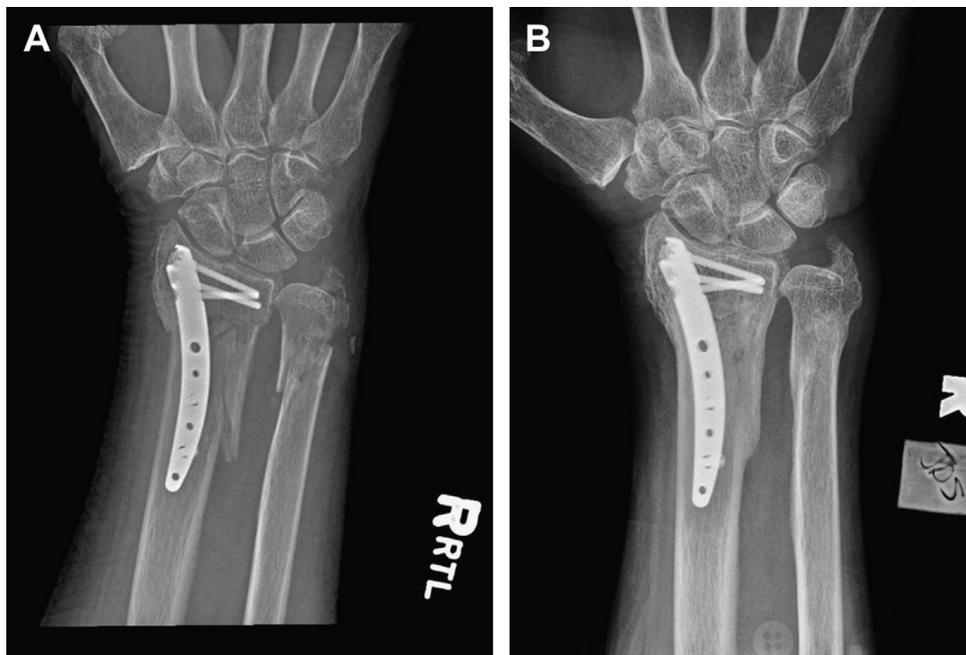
(A) Three-week follow-up of a distal radial fracture with metaphyseal extension treated with an intramedullary nail. (B) Six-month follow-up radiograph shows union of the fracture. (From Harreld K, Li Z. Intramedullary fixation of distal radius fractures. *Hand Clin* 2010;26(3):367; with permission.)
